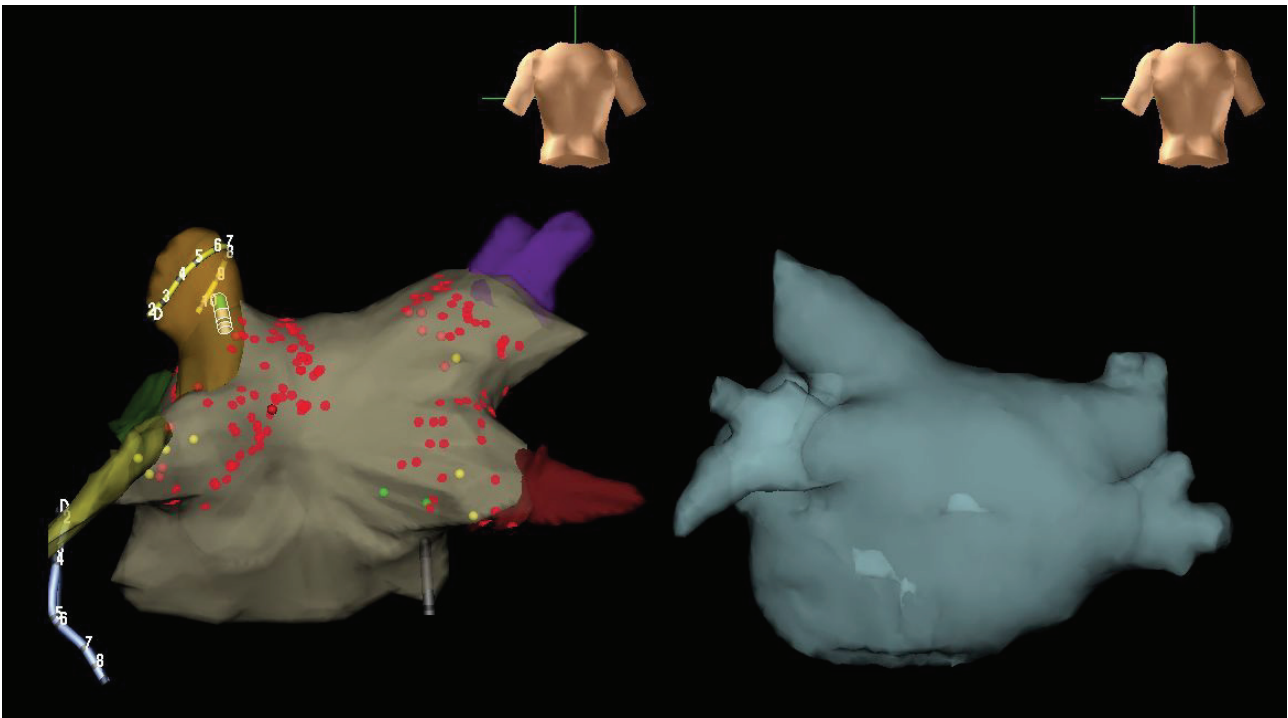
Scheme of circumferential lesions created in patients with paroxysmal atrial fibrillation undergoing catheter ablation and isolation of pulmonary veins. Ablation sites (red dots) are projected on 3D map of the left atrium in posterior view obtained by means of Nav X mapping system (St. Jude Medical). On the right side of the panel is corresponding CT angiogram of the left atrium and pulmonary veins.
